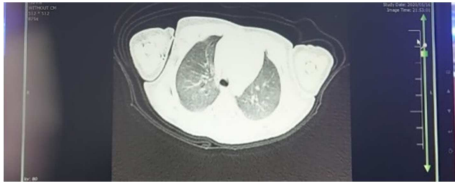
HRCT of neonate case 1 shows diffuse and bilateral ground glass opacities.
